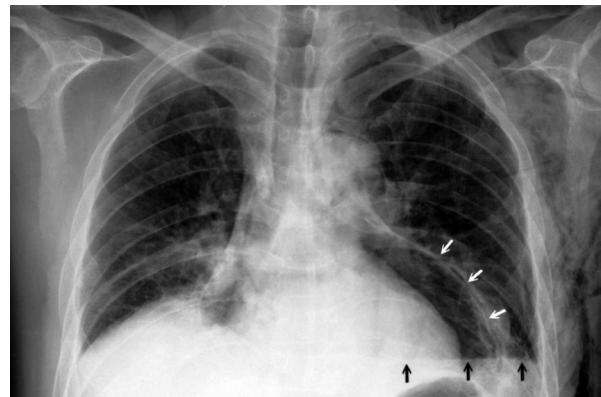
Chest radiograph after removal of the pericardial drainage catheter. Black arrows denote an air-fluid level in the left lower field which represents hydropneumothorax. White arrows indicate 2 radiopaque lines outlining the pericardial sac. The outer line represents the visceral pleura and the inner line is the pericardium. Concurrent pneumopericardium and pneumothorax is demonstrated. Subcutaneous emphysema in the left-side chest wall and neck was also found.
